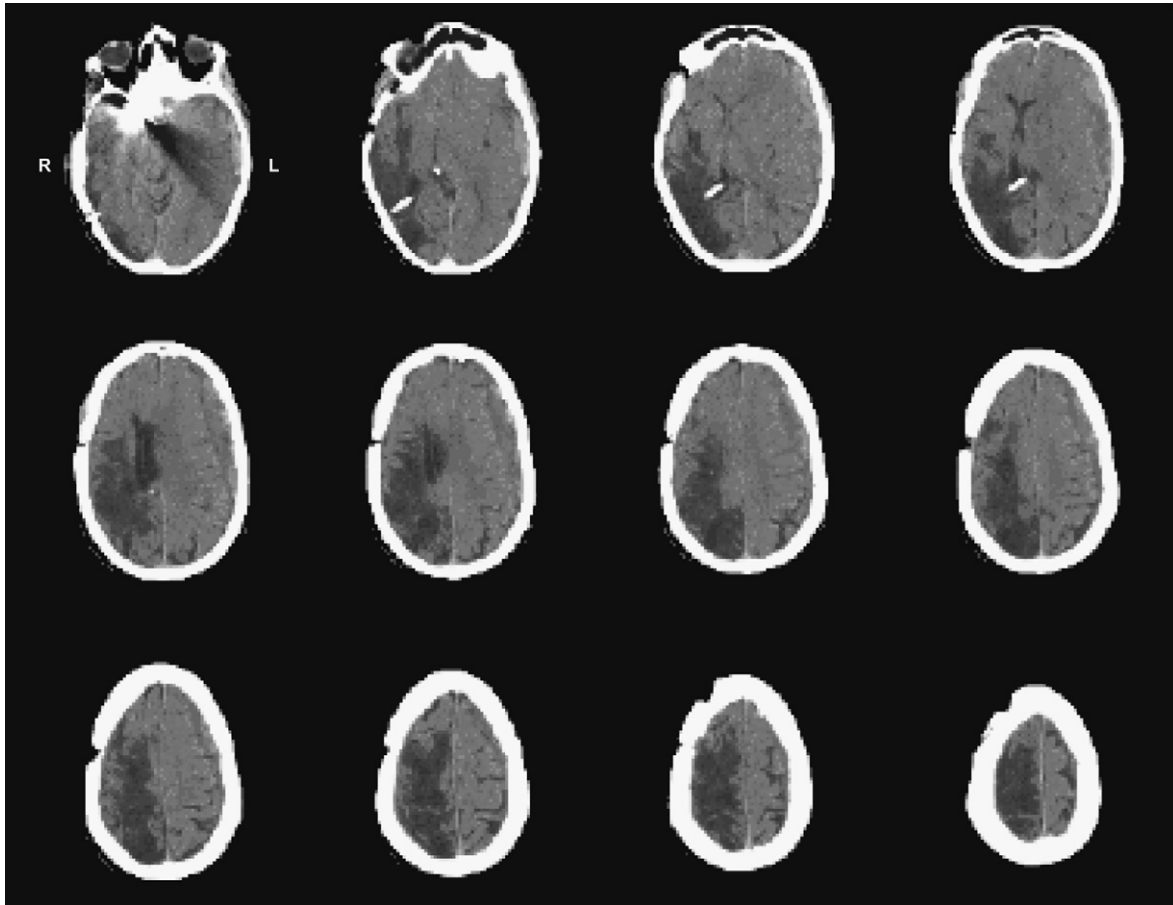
CT scan (2005) showing clip artefacts in the right frontal region, a ventricular peritoneal drain from the right lateral ventricle, a large cortical infarct in the right hemisphere, and a SDH in the left hemisphere.
